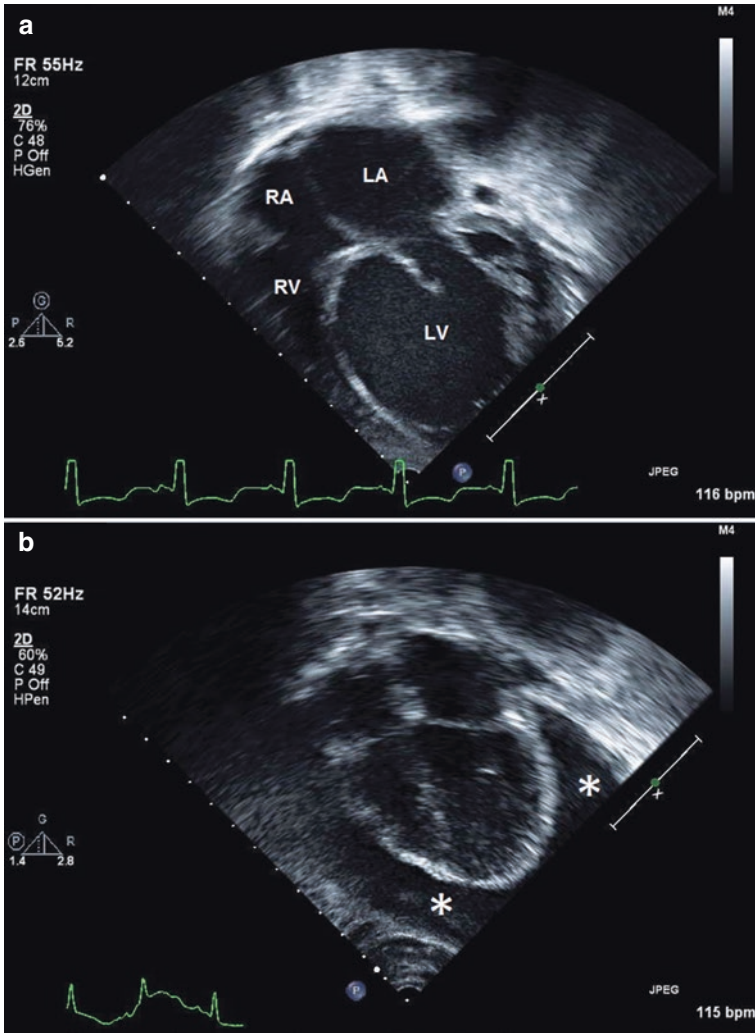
Echocardiographic abnormalities in children with heart failure. (a) Marked dilation of the left atrium (LA) and left ventricle (LV) in a 9-year-old girl with newly diagnosed dilated cardiomyopathy. The right atrium (RA) and right ventricle (RV) are unaffected. (b) A large pericardial effusion (asterisks) in a 7-year-old girl with acute myocarditis
